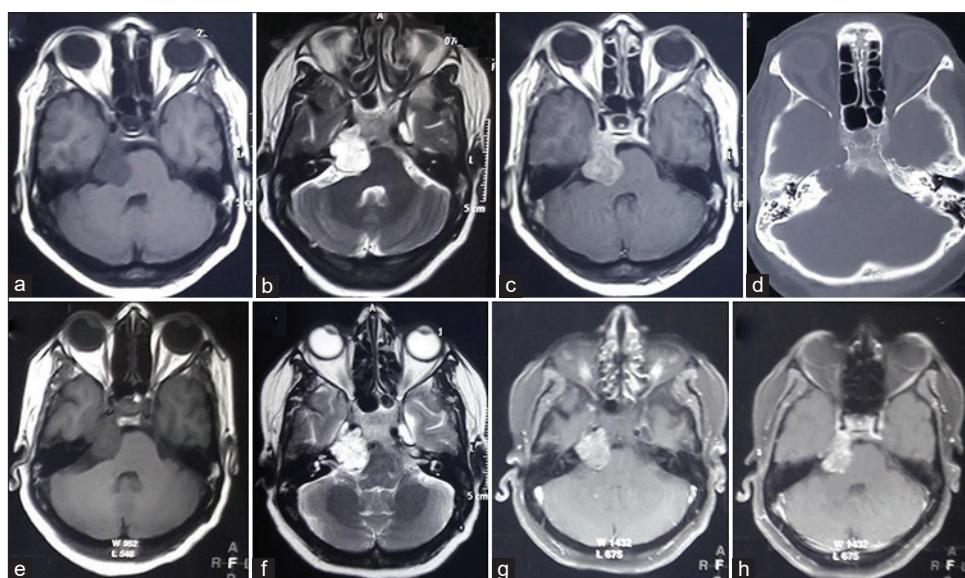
Upper row: MRI showing tumor straddling across the petrous apex from middle fossa to the posterior fossa. (a) Tumor is hypointense on T1, (b) hyperintense on T2, and (c) showing contrast enhancement. (d) Note the bony erosion of the petrous apex without any calcification. Lower row: (e-h) serial MR images in the follow-up showing tumor with similar size on volumetric analysis.
